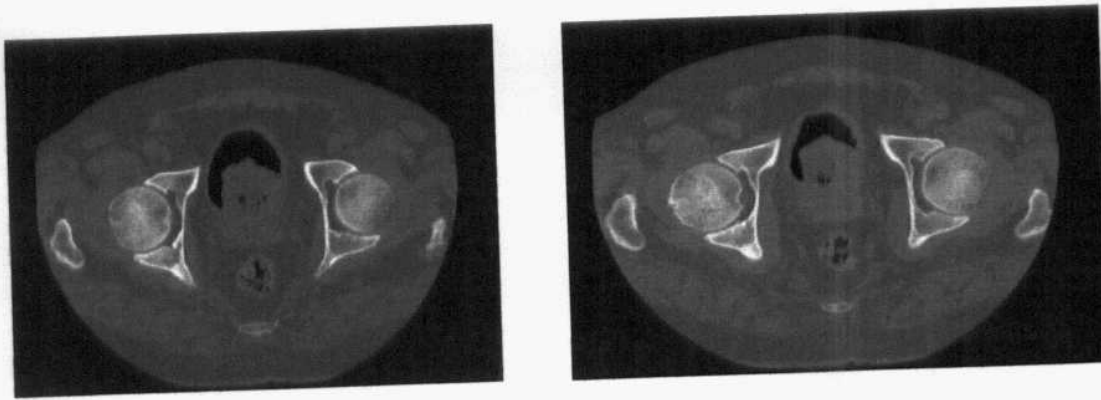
Axial CT scan (air contrast)
